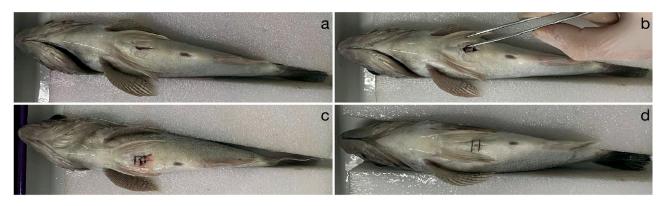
Minimally invasive surgery performed on *Sebastes schlegelii*. (a) Minimally invasive laparotomy; (b) ultrasonic pinger implanted in the abdomen; (c) incision closed with needle and thread; (d) incision closed with disposable skin staples
